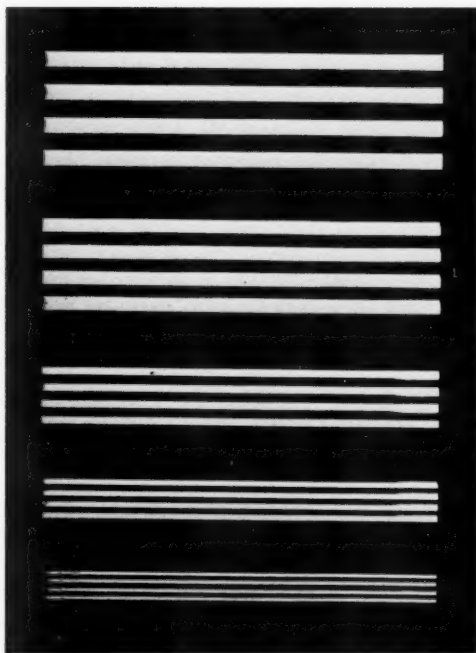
General Electric lead reticle. The radiograph shows the different spatial frequencies which vary from 12 to 50 line pairs per inch.
